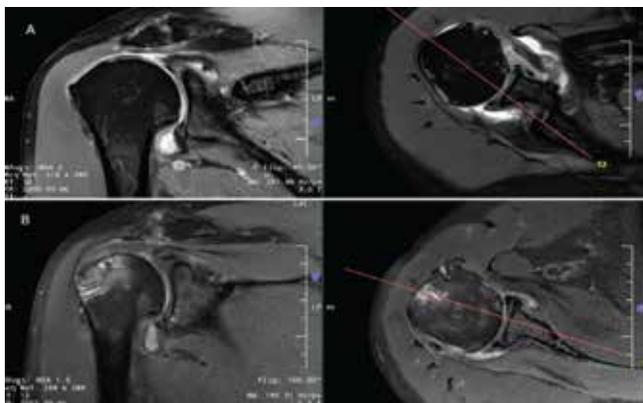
A Preop MRI right shoulder coronal and axial images showing Supraspinatus tear with Patte 3 retraction, Infraspinatus tear.
